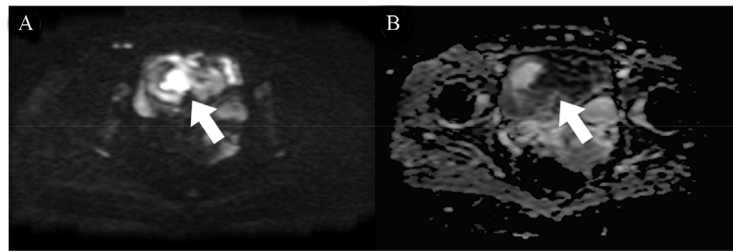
DWI (A) and ADC map (B) at the same section as Fig. 2. Diffusion was restricted in the dorsal part of the cystic lesion (arrows). DWI, diffusion weighted imaging; ADC, apparent diffusion coefficient.
